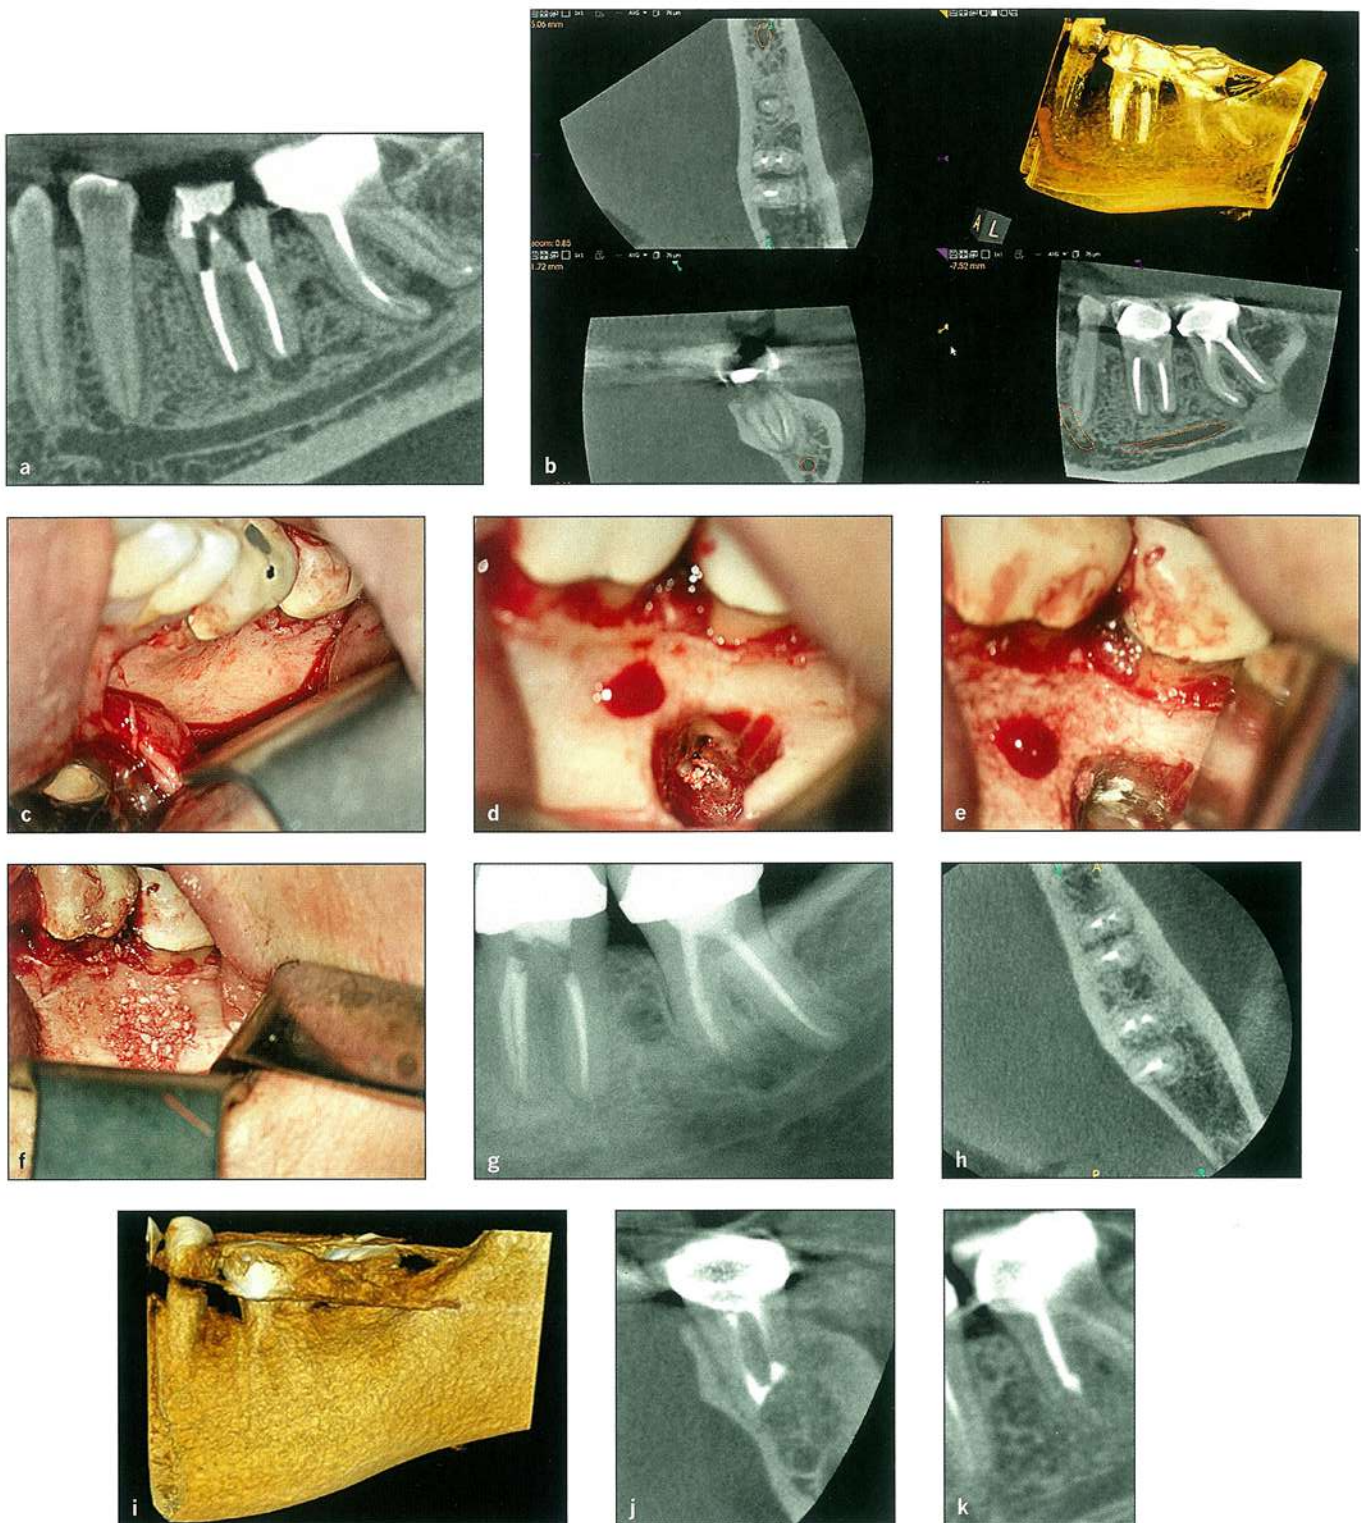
(a) CBCT sagittal view of a mandibular left second molar that was referred for periapical microsurgery. The first molar was retreated nonsurgically. (b) CBCT of the axial, coronal, and sagittal views and a 3D rendering demonstrating the proximity of the IAN to the mesial root of the second molar. (c) Clinical photograph after surgical flap reflection showing the buccal cortical plate. (d) Osteotomy and resection of the mesial root. (e) Clinical photograph demonstrating the mineral trioxide aggregate (MTA) root-end filling. (f) Periapical defect grafted with Puros allograft material (Zimmer) before placement of CopiOs membrane. (g) Immediate postsurgical radiograph. (h to k) Eighteen-month postoperative CBCT images demonstrating complete remodeling of the defect and the buccal cortical plate.
